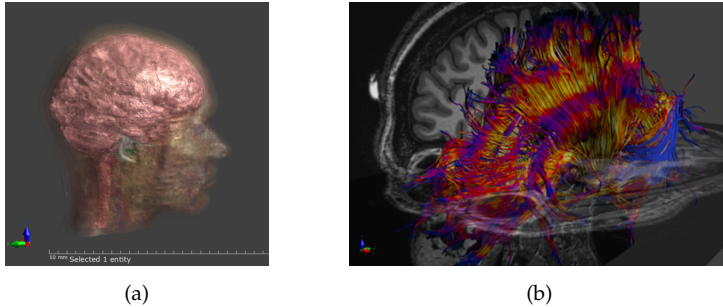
The MIDA head model (left), as well as underlying MRI image data and DTI tractography (right).
